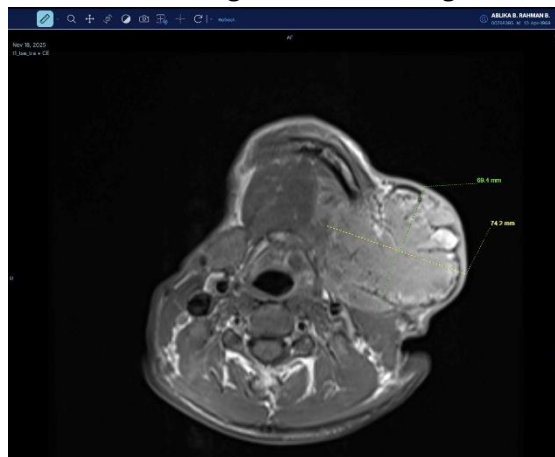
Contrast-enhanced MRI of the neck demonstrating a heterogeneous lobulated mass arising from the left parotid gland, measuring approximately $5.8 \times 7.0 \times 5.6$ cm, with erosion of the left mandibular bone and compression of the ipsilateral submandibular gland.
